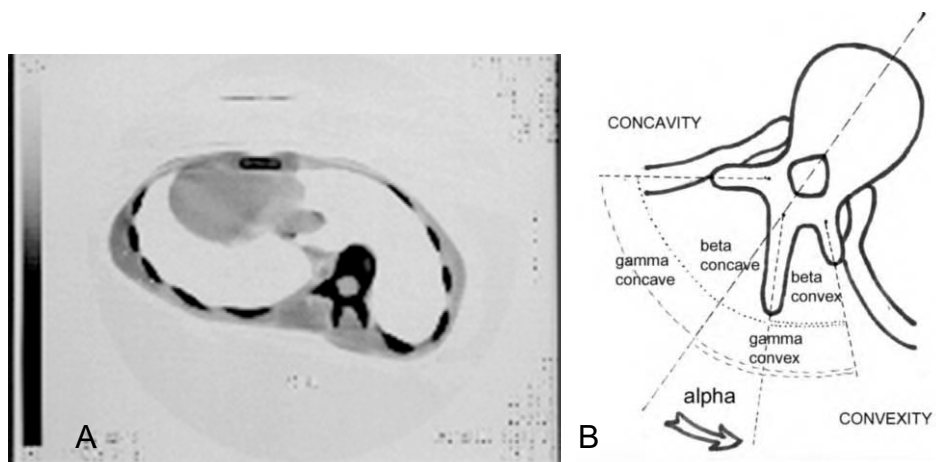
A) CT scan of apical vertebra of right thoracic scoliosis (top view). B) Definition of angles.
